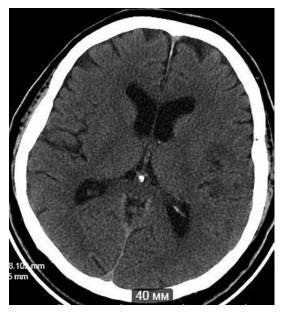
Computed tomography of the brain of patient B., 63 years old, after thrombolysis before thrombectomy
